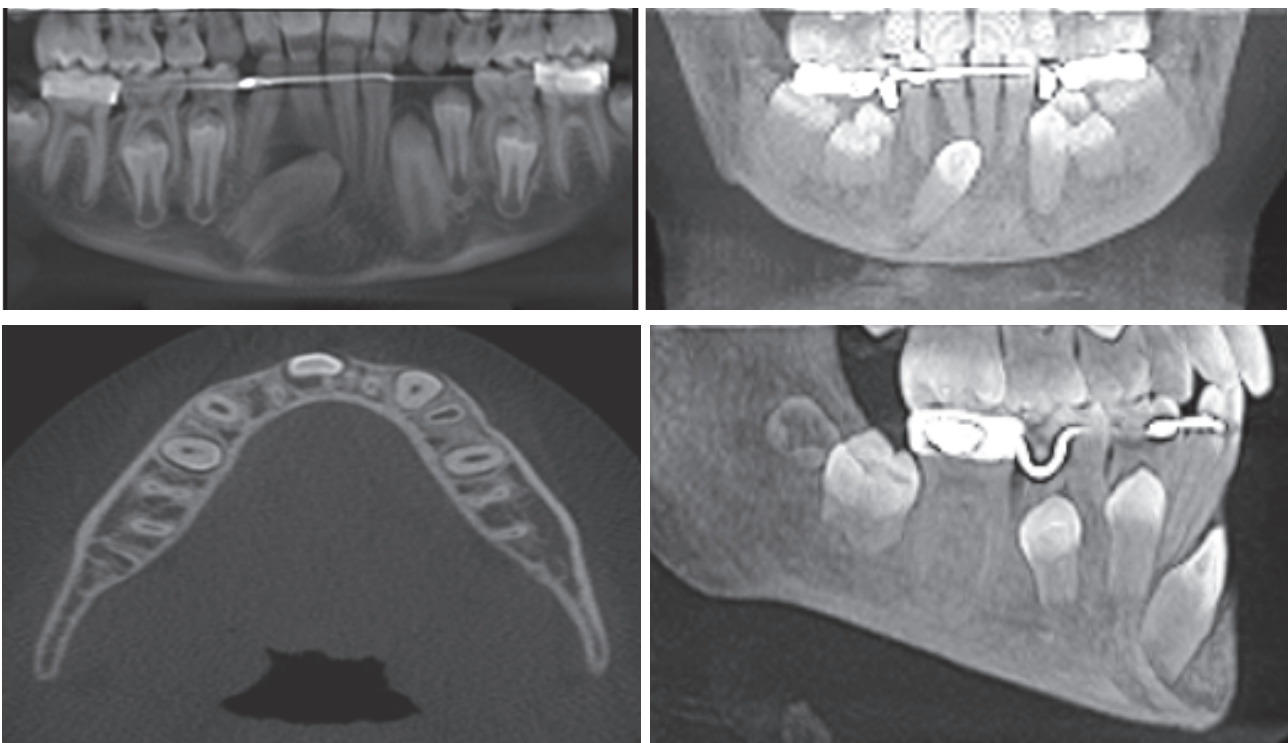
Pre-operative CBCT.
